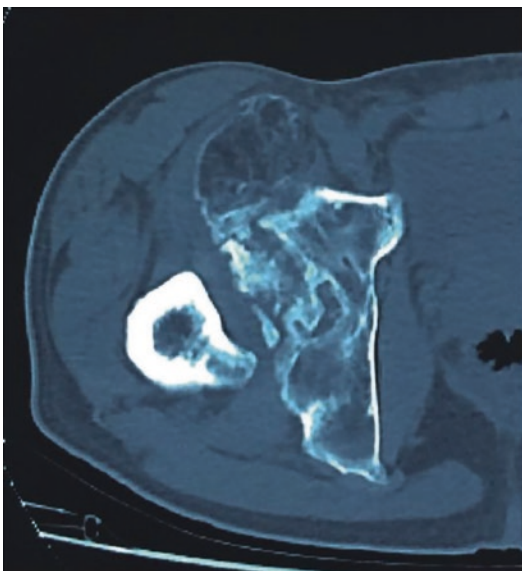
Computed tomography in developmental dysplasia of the hip. A large osteophyte in ventral acetabulum is visible
